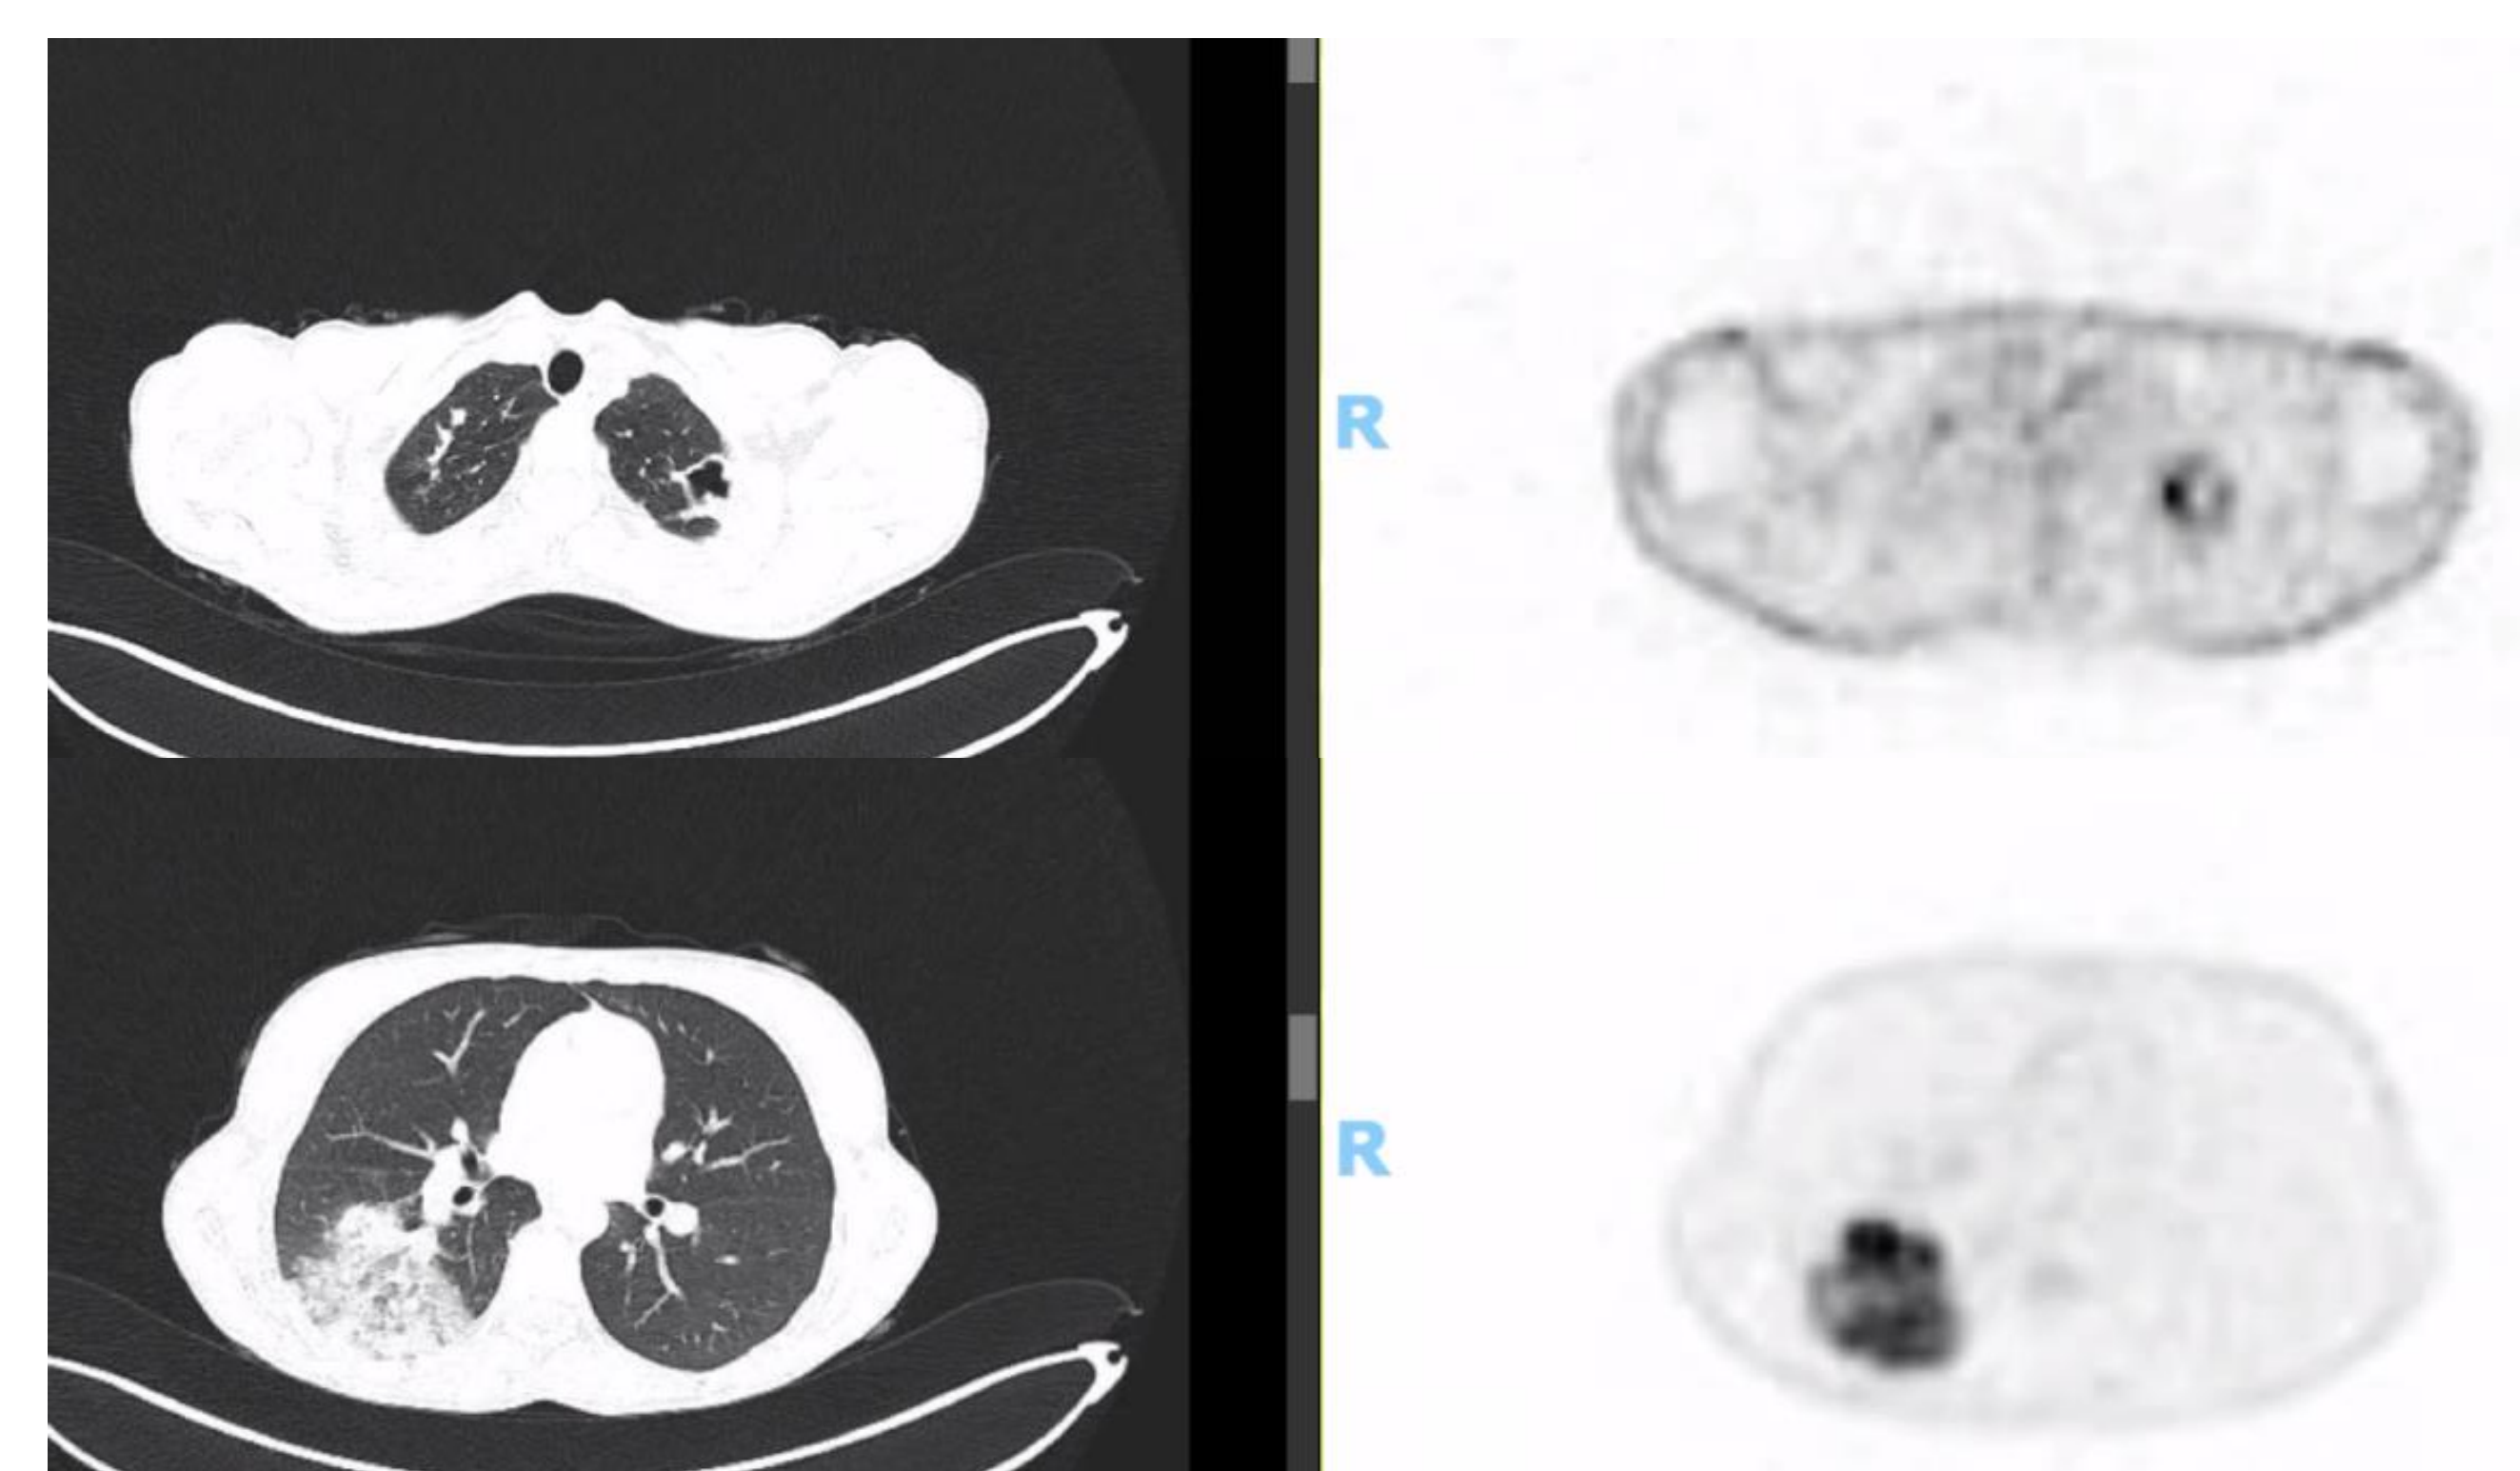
PET-CT showing FDG hypercaptation of the bilateral nodules and cavitations. It also demonstrates the development of right lower lobe pneumonia following bronchoalveolar lavage procedure.
